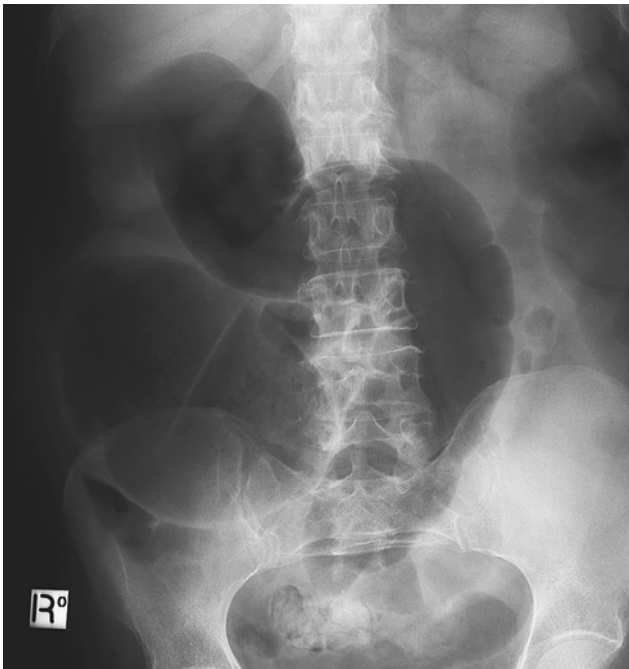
A plain x-ray demonstrates the dilatation of the colon.
